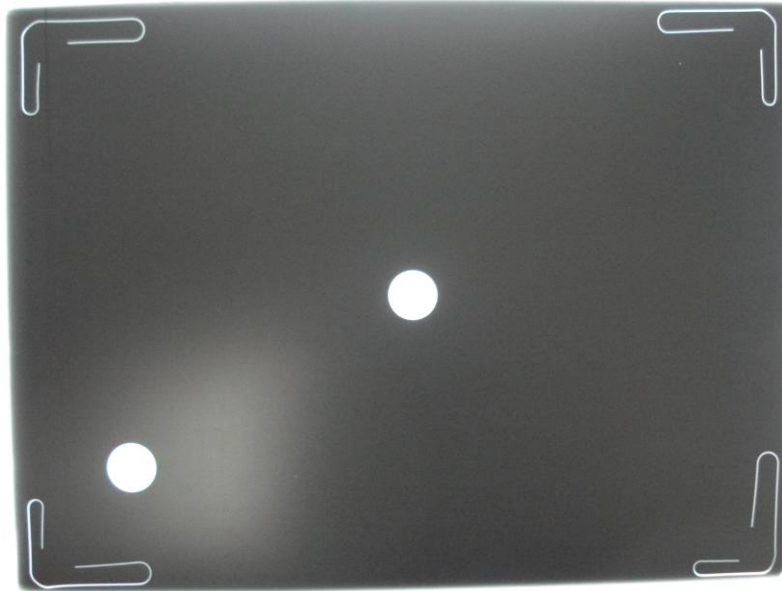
Radiograph of X-ray beam alignment obtained with the test cassette, paper clips and coins.
